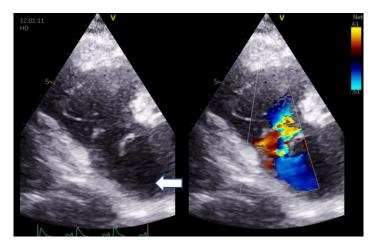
Two-dimensionaltransthoracicechocardiographywithsimultaneouscolor Doppler revealedtricuspidchordaetendinae rupture, with the anteriorleaflets of the tricuspid valve turning over into the left atrium during systole (arrow), alongwithsignificant
